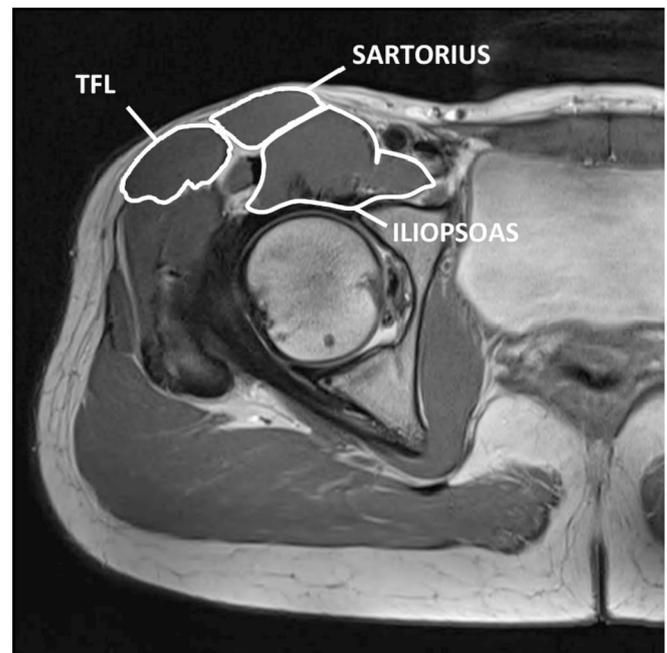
Iliopsoas, sartorius and tensor fascia latae (TFL) muscle cross-sectional areas traced on an axial T1 MRI.
